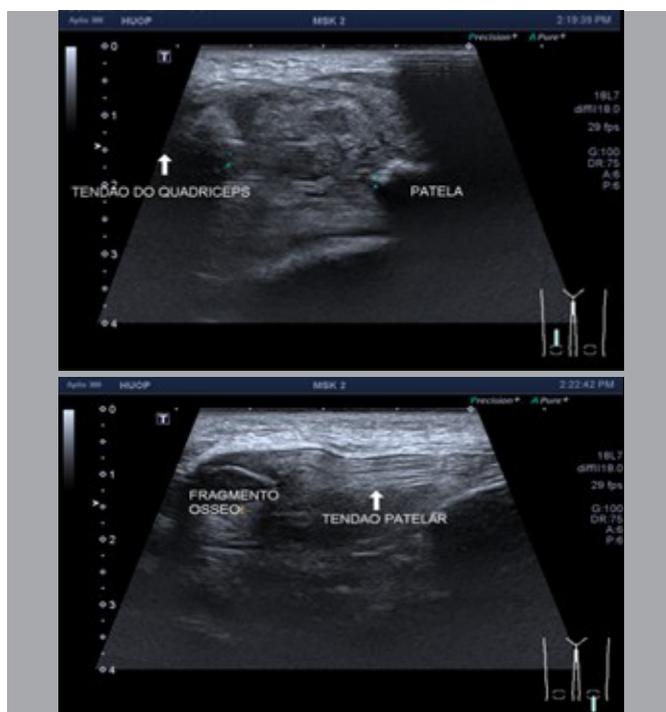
Ultrasound examination of the knees. Left: signs of total quadriceps tendon rupture with a gap measuring approximately 20 mm and signs of associated hematoma. Right: rupture of the proximal insertion of the patellar tendon with an associated patellar bone fragment, a large hematoma on the left, and a large cranial deviation of the patella.
